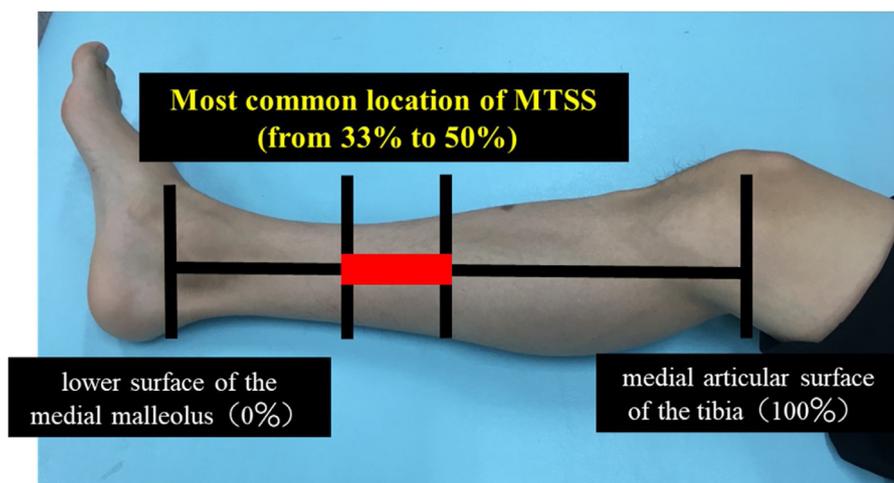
Ultrasonographic measurement locations. The length of tibia was measured from the lower surface of the medial malleolus (0%) to the medial articular surface of the tibia (100%) by a digital caliper. We identified the most common location affected by MTSS as 33% to 50% from the lower surface of the medial malleolus.
